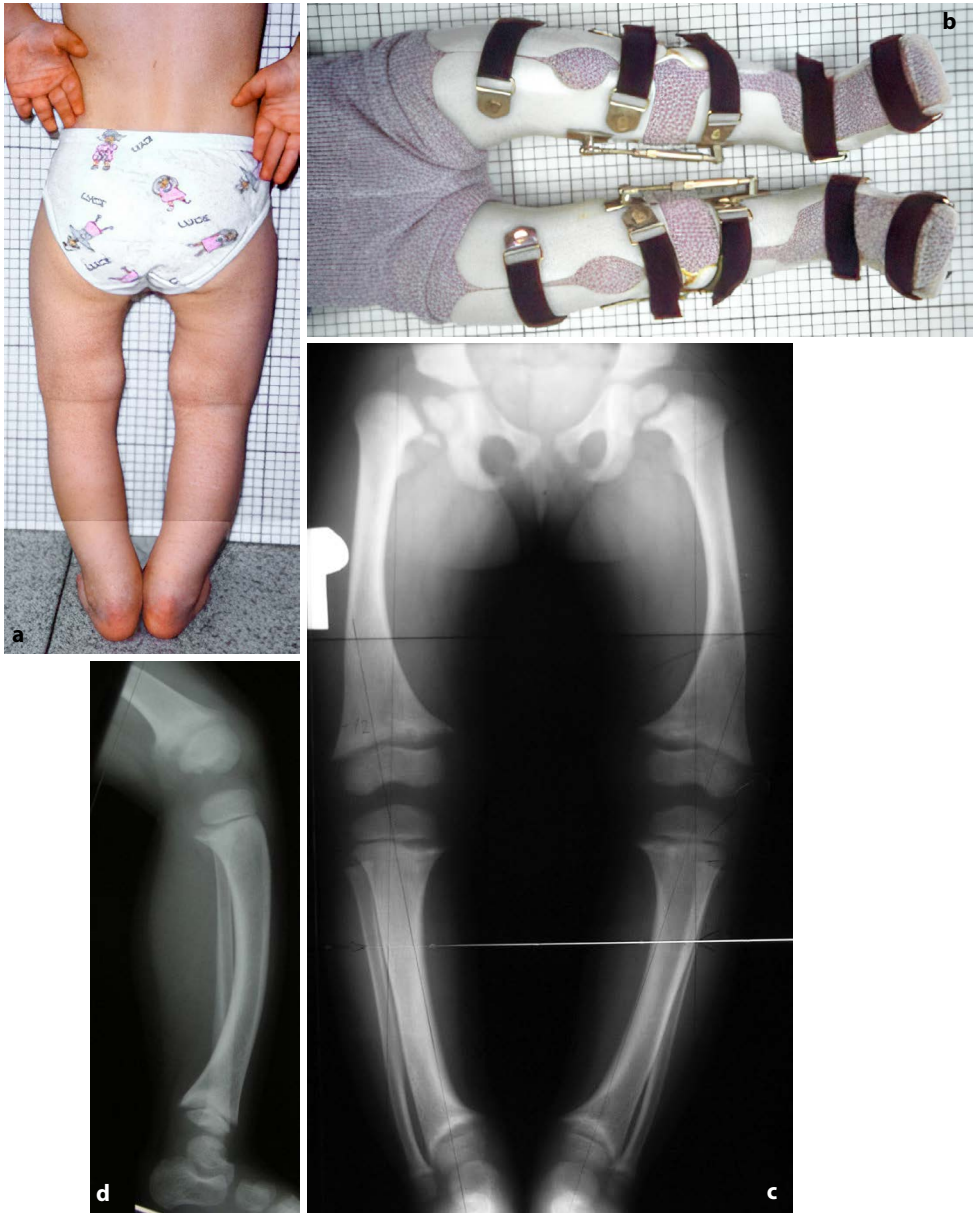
a. standing lower limbs from the back of a girl at 3 years, see short upper limbs, intercondylar distance 4 cm, in supine position it was 3 cm; b. new lower limb braces with flexion preload in frontal plane; c. standing lower limb tele-radiograph: tibiofemoral angle right/left is $3^{\circ}/4^{\circ}$; note the bilateral varus of the femoral necks, bilateral varus of the supracondylar and supramalleolar areas, marked overgrowth of the distal ends of both fibulae, enlargement of the zone of provisional calcification and metaphyses, and cup-shaped distal tibial metaphyses; d. ventral bowing of the tibia and typical rachitic changes.
